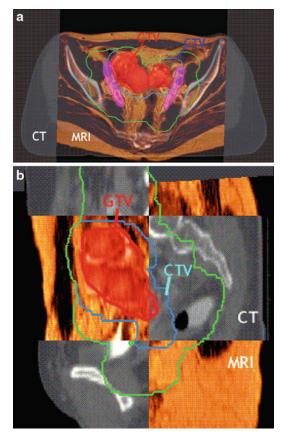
A 27-year-old female with a large squamous cell carcinoma of the cervical stump. MR-CT fusion helps identify and delineate the gross disease. Axial view (a) and Sagittal view (b)
